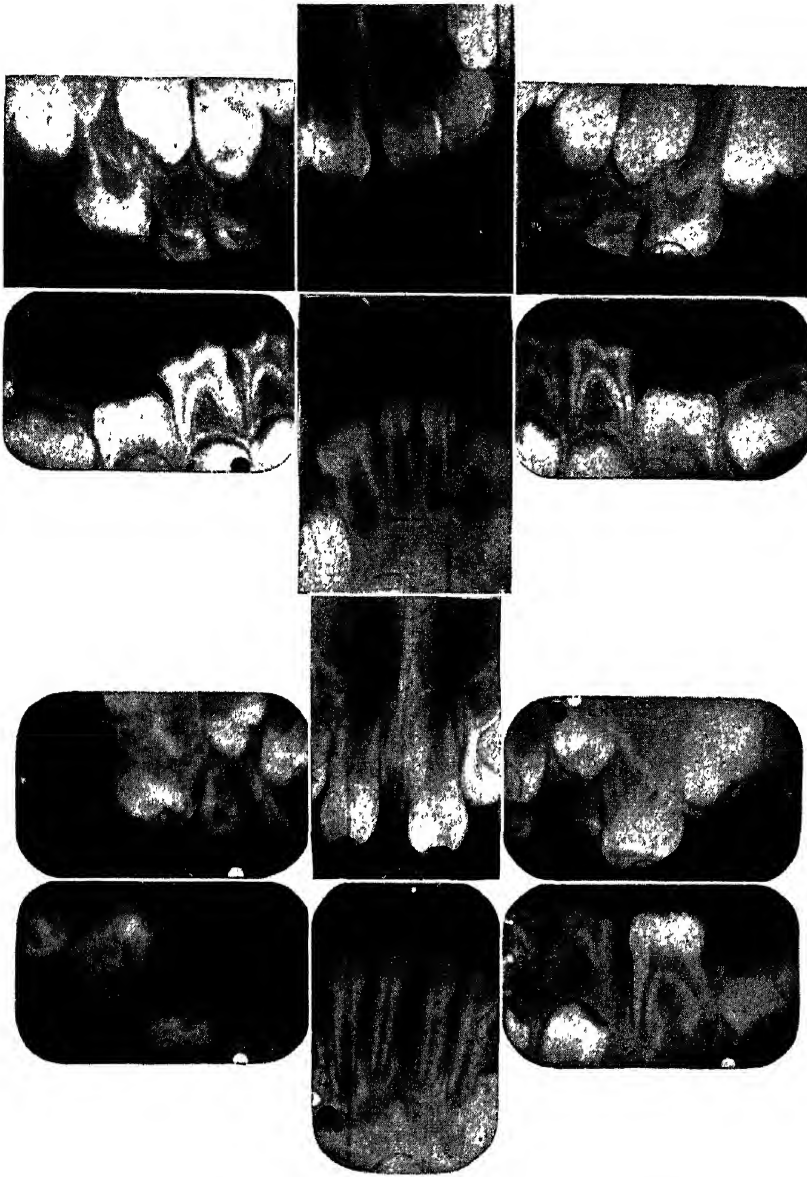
Intraoral roentgenograms of patients with congenital syphilis, showing unerupted permanent central incisors and first molars. Note the convergence of the proximal surfaces and the smaller size of the teeth. *A*, The permanent central incisors are screwdriverlike; the permanent first molars are mulberrylike. Note the irregularity of the incisal third and the occlusal surface. *B*, Note the notch in the unerupted permanent upper central incisors. The permanent first molars are the bud form described by Pfluger. (B. G. Sarnat and N. W. Shaw: *Am. J. Dis. Child.*)
